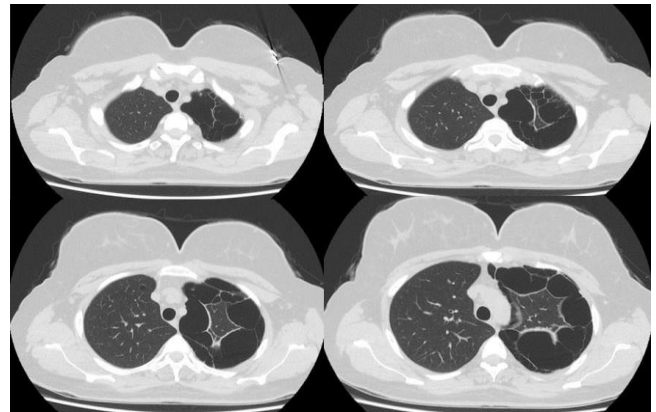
A CT scan of the thorax showed multiple cystic lesions on the pleural surfaces of both lungs, with most of them on the left side
